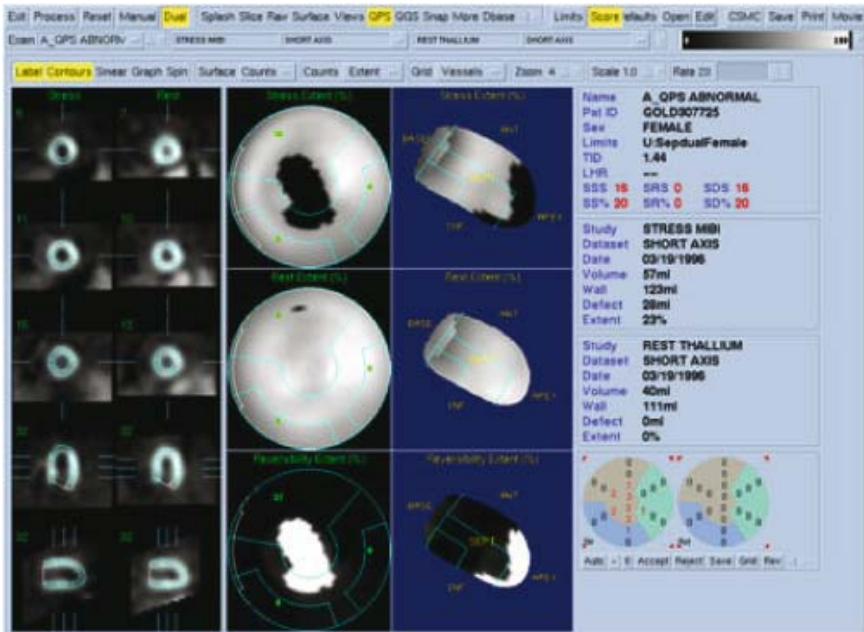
Quantitative perfusion SPECT display for a patient with ischemia in the mid-left anterior descending coronary artery territory.
